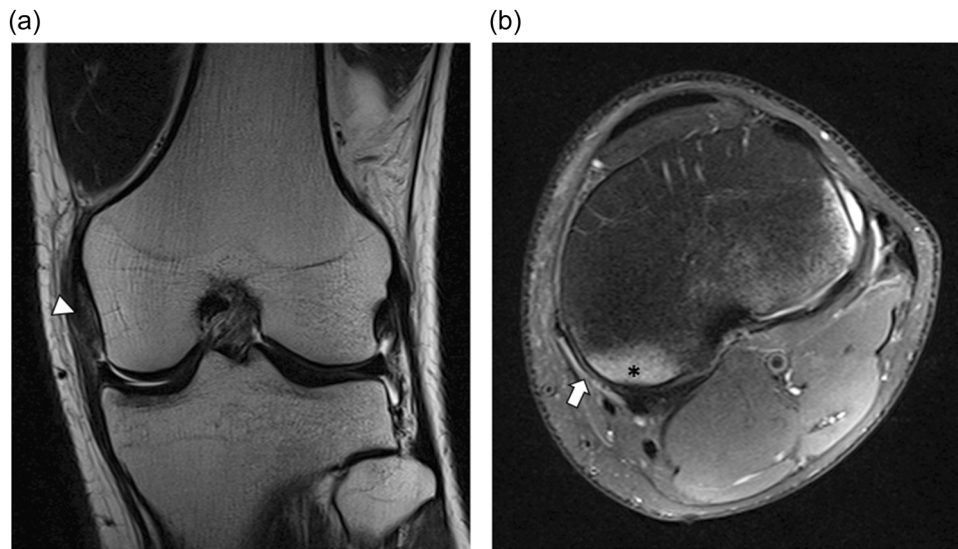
Coronal T2-weighted (a) and axial proton-density-weighted fat-saturated (b) magnetic resonance images of a 24-year-old male patient with an associated intermediate-grade medial collateral ligament (white arrowhead in a) and posterior oblique ligament incomplete lesion (white arrow in b). Note the bone contusion in the medial tibial plateau (* in b).
